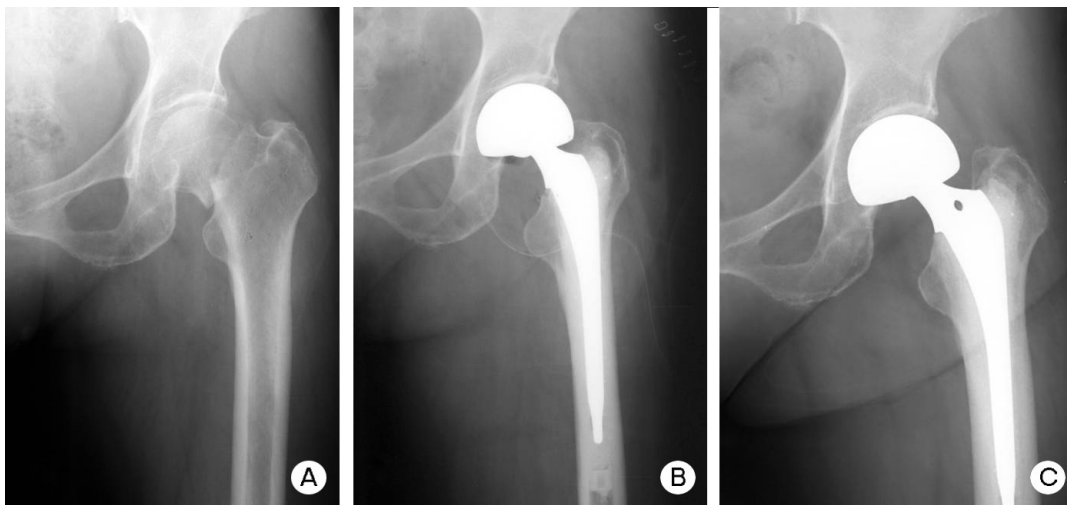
(A) Preoperative radiograph of a 75 year-old female with left displaced femoral neck fracture. (B) Postoperative radiograph of cemented bipolar hemiarthroplasty via conventional posterolateral incision in same patient. (C) Radiograph taken 34 months postoperatively showing no loosening around femoral stem; the patient’s Harris hip score at this time was 83.
